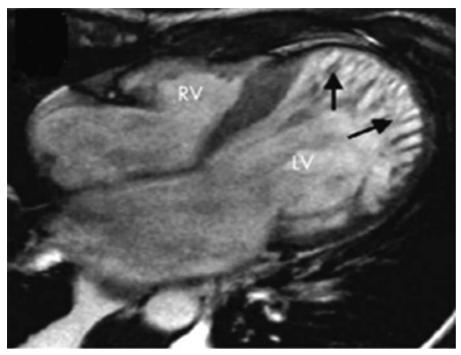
Magnetic resonance image demonstrating in morphologic detail left ventricular apex trabeculation. LV, left ventricle; RV, right ventricle.
